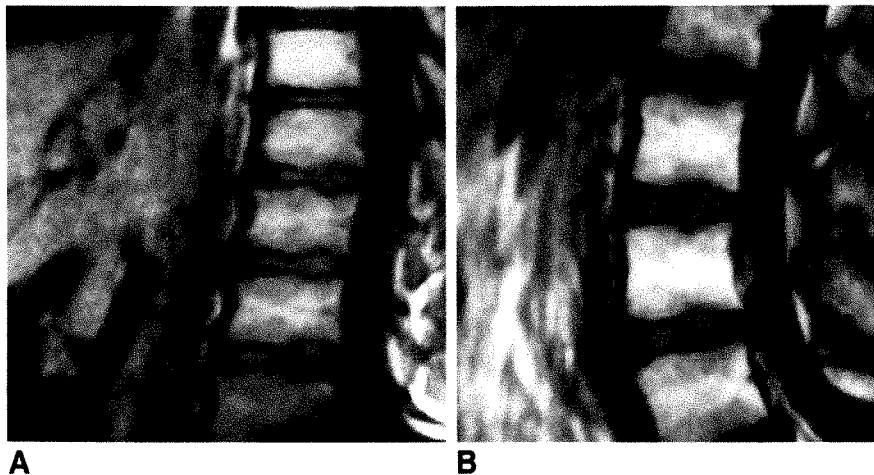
A and B, T1-weighted images (300/30) of 17-year-old patient with Hodgkin disease before (A) and 14 months after (B) 4050 rad (41 Gy) to lumbar spine. Peripheral zone of intermediate/low signal intensity surrounds central marrow fat.
